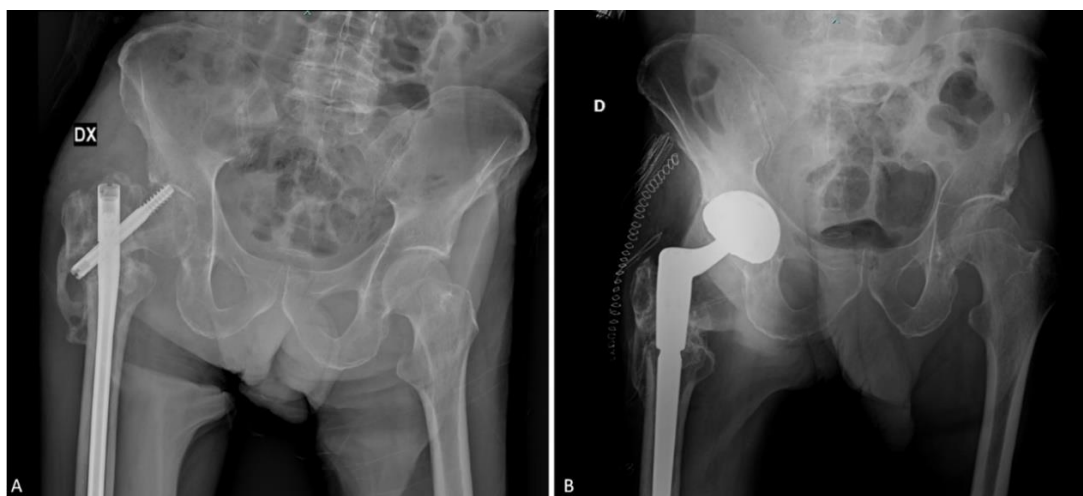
X-ray imaging showing femoral gamma nail (A) and total hip arthroplasty (B).
